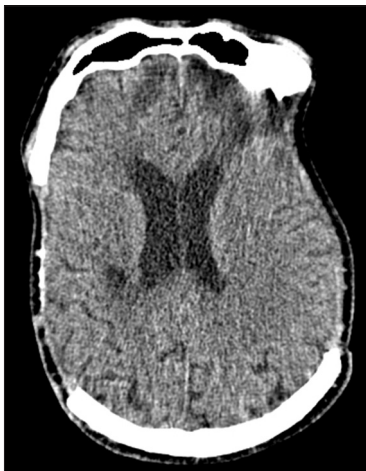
CT scan at the 76th day in the hospital
